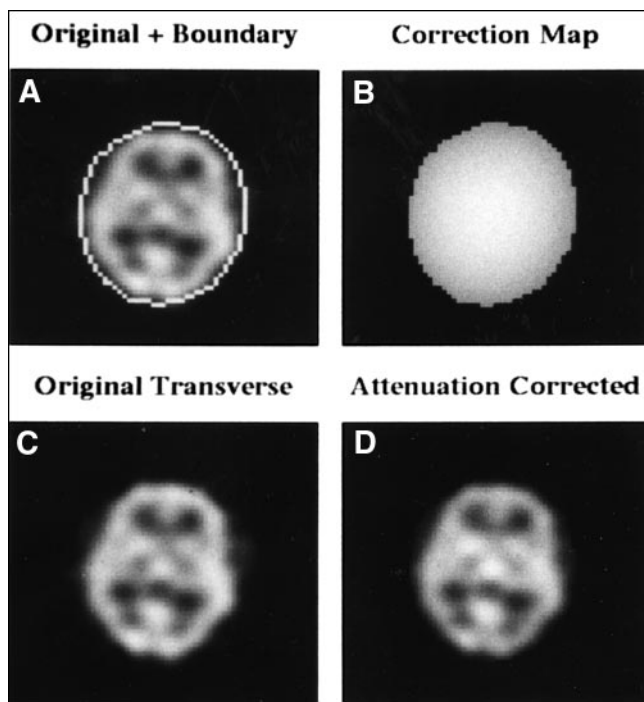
Chang postprocessing attenuation correction method. (A) Original uncorrected central transverse slice from a 128×128 ^{99m}Tc -HMPAO brain SPECT study with a manually determined boundary of the head overlaid. (B) Correction map $C(x,y) = M/S \exp(-ml_q)$, $q = 1, 2, \dots, M$, where x,y is the pixel location within the boundary, M is the number of projection views, and l_q is the depth of x,y within the boundary for projection angle q . (C) Uncorrected slice and (D) attenuation-corrected slice. Note the increase in activity toward the center of the brain. To avoid under- or overcorrection, the boundaries must be accurately defined (preferably in an automated fashion).
